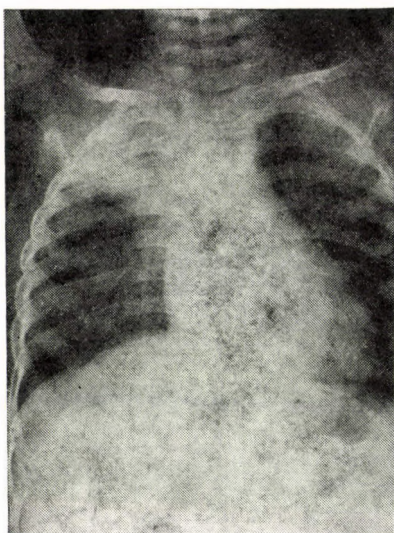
Chest X-rays of N. I. (2-year-old boy). Density in the right upper lung
